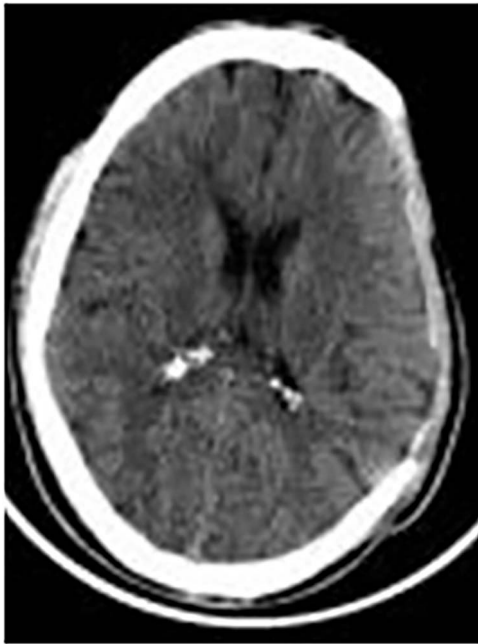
CT scan after the second operation.
